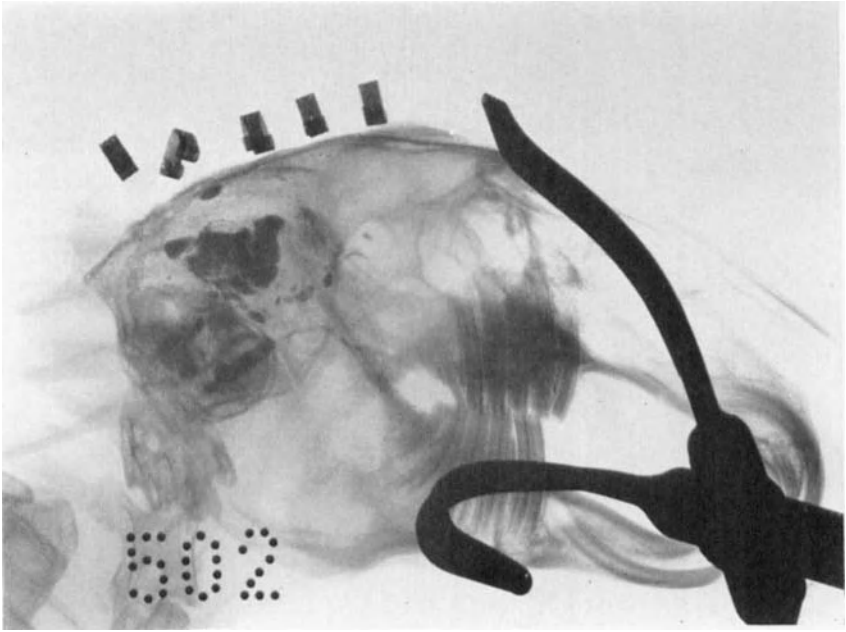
Radiograph of artificial brain tumour.
